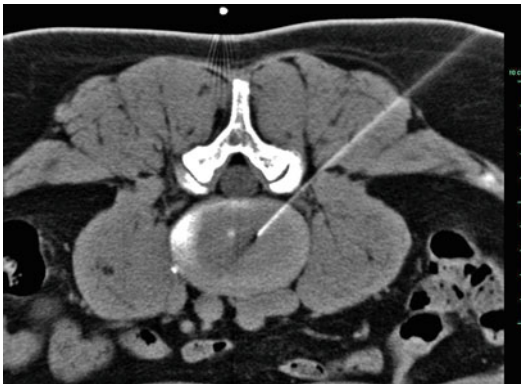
CT-guided discography: positioning of the puncture needle
